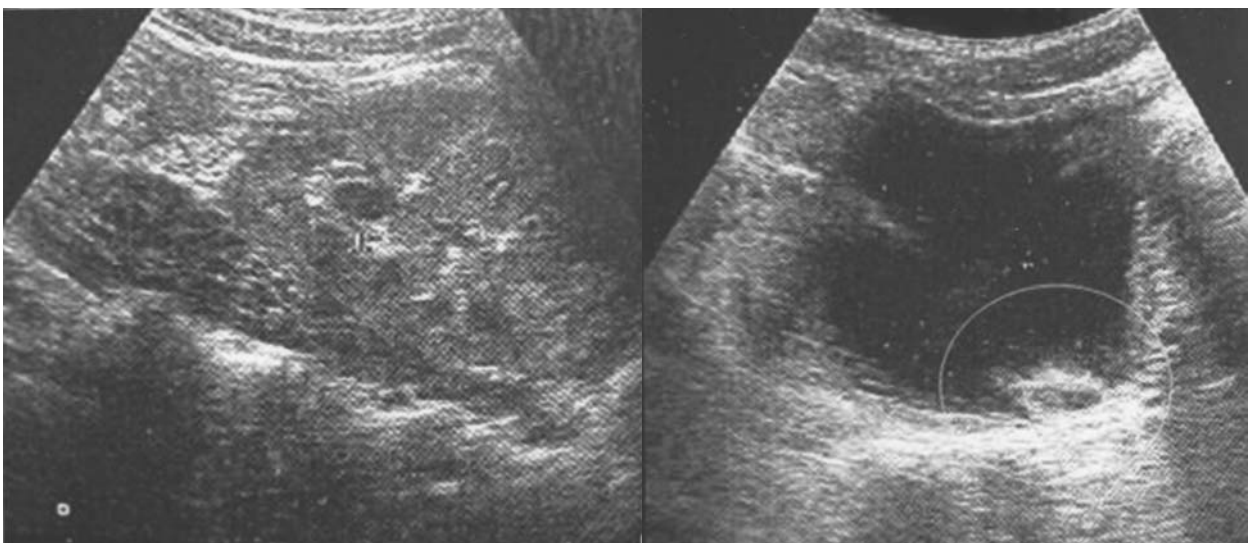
Postoperative ultrasonography showing absence of dilation in left kidney and collapsed intravesical ureter.
